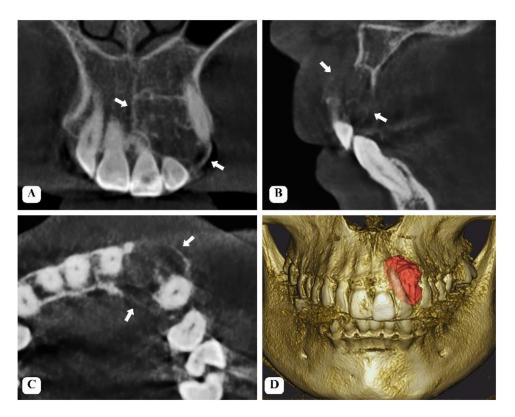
Case 2, Multiplanar Reformation (MPR) CBCT images. (A) coronal view, (B) sagittal view, (C) axial view, (D) 3D view with lesion segmentation.
